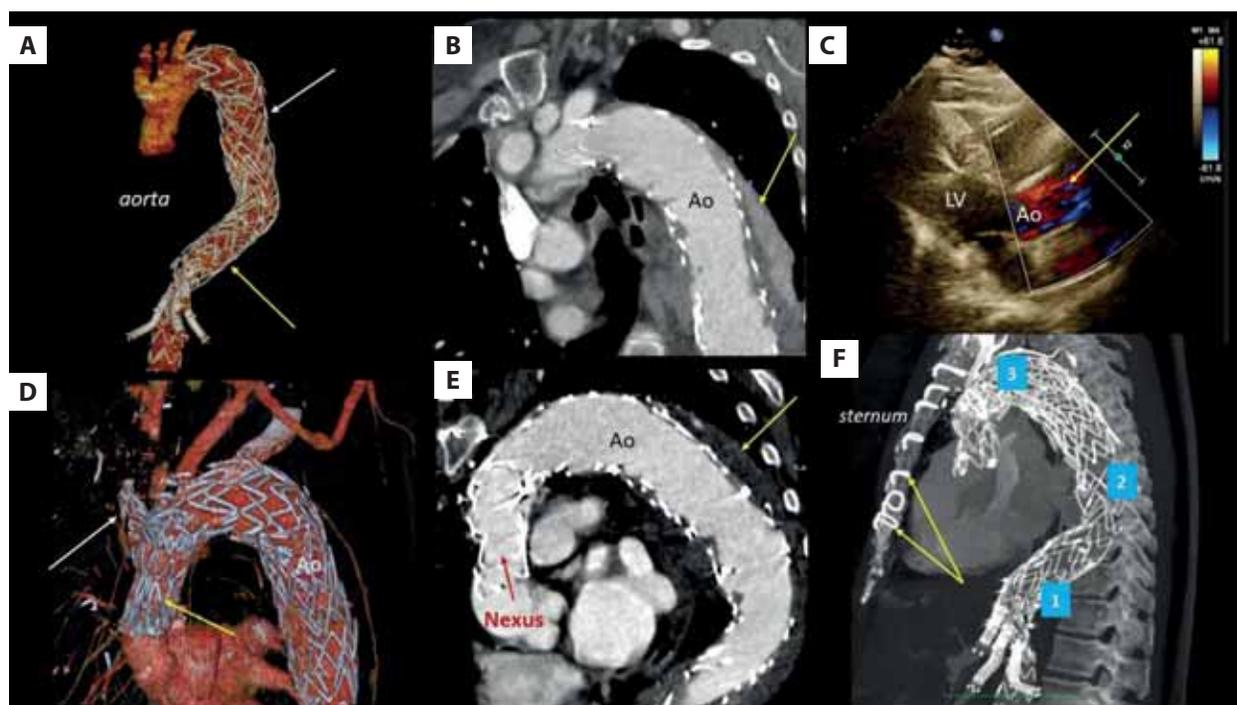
Computed tomography angiography and transthoracic echocardiography in a patient with a history of four procedures on the aorta. A. Computed tomography angiography of the aorta in 3D option: thoracic stent graft below the left subclavian artery (white arrow) and thoracoabdominal stent graft with visceral branches (yellow arrow). B. Computed tomography angiography: endovascular leak (arrow). C. Transthoracic echocardiography (color Doppler, long axis view): blood flow in the ascending aorta graft (arrow); see also Supplementary material, *Video S1*. D. Computed tomography angiography of the aorta in 3D option after the procedure: Nexus aortic arch stent graft (yellow arrows) and a branch to the brachiocephalic trunk (white arrow). E. Computed tomography angiography after the procedure: no endovascular leak (arrow). F. Computed tomography angiography: three aortic stent grafts in one patient (1–3); metal sutures on the sternum after cardiac surgery (arrows)
